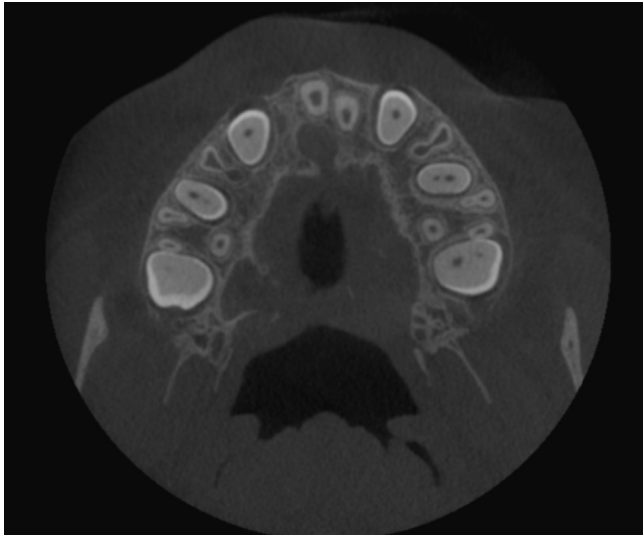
Maxillary CBCT 1 year after the right alveolar bone grafting using GlassBONE™ showing an alveolar bone continuity.
